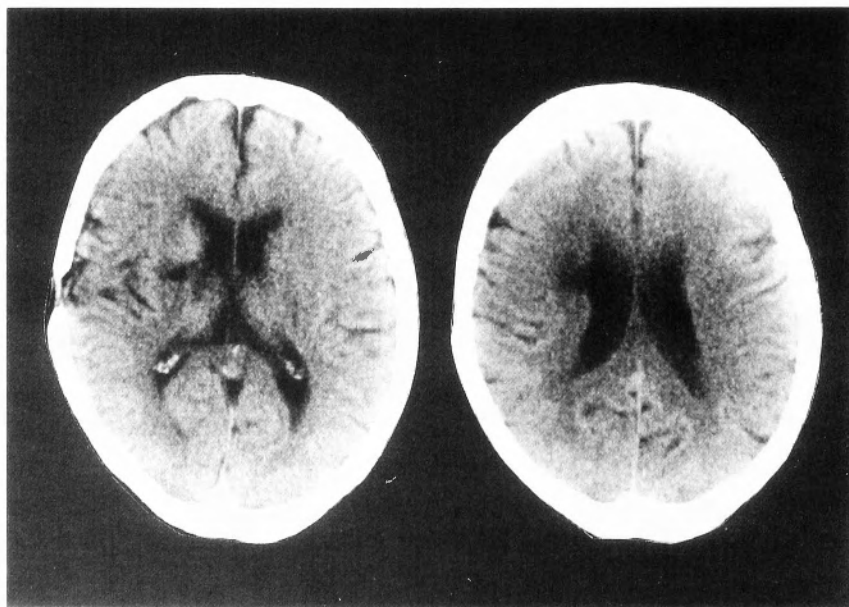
CT disclosed low density area of the right lentiform nucleus and right corona radiata.
